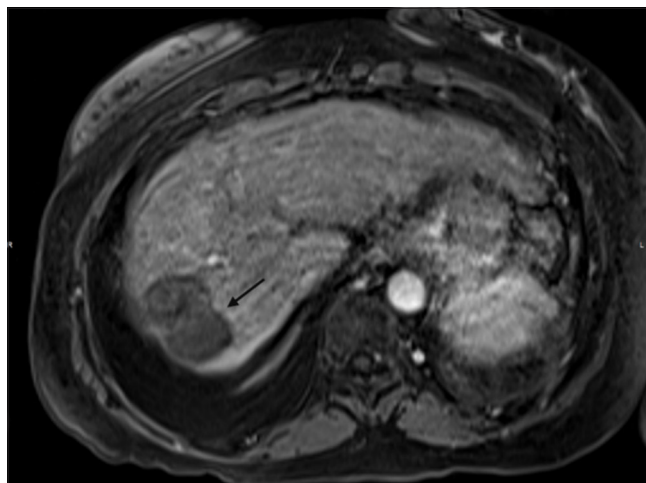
A 62-year-old man with cirrhosis complicated by diuretic-resistant ascites, found to have hepatocellular carcinoma during workup for transjugular intrahepatic portosystemic shunt. Magnetic resonance imaging of the liver T1 post-contrast arterial phase image 8 weeks after ablation showing 45 mm × 33 mm ablation cavity (black arrow) without any arterial enhancement.
